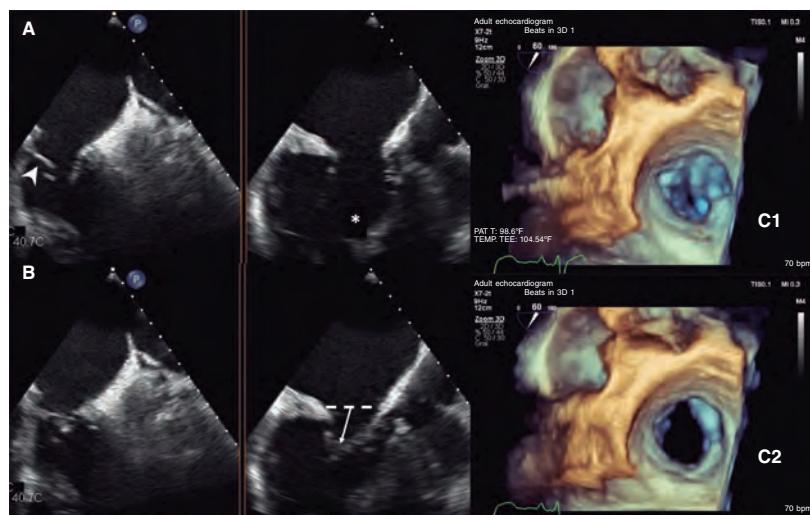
Detailed assessment of the anatomy of the tricuspid valve on a 2D and 3D transesophageal echocardiogram. X plane views in 55-degrees (left), and 145-degrees (middle) in end-diastole (A), and end-systole (B). Significantly dysplastic leaflets (arrowhead) with Ebstein-like apical displacement of the insertion, and anomalous chordae tendineae implantation (asterisk) causing tension and bulge (arrow). C: mitral valve assessment with 3D zoom showing a large coaptation gap predominantly between the septal and the posterior leaflets in end-systole (C1) and end-diastole (C2).
